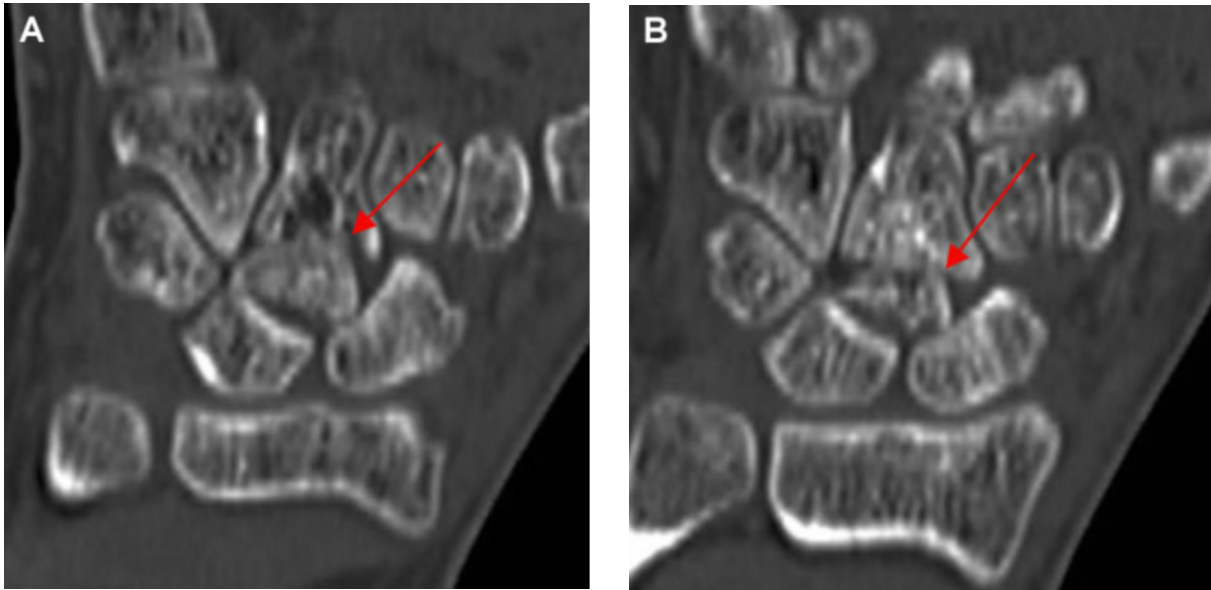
Coronal CT images of the right wrist show the capitate fracture. The proximal fracture fragment (arrow) rotated 180 degrees.
